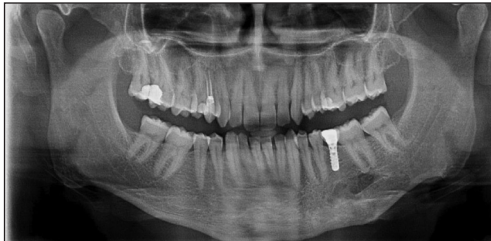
The panoramic radiograph which shows 2 years-follow up of the implant.
